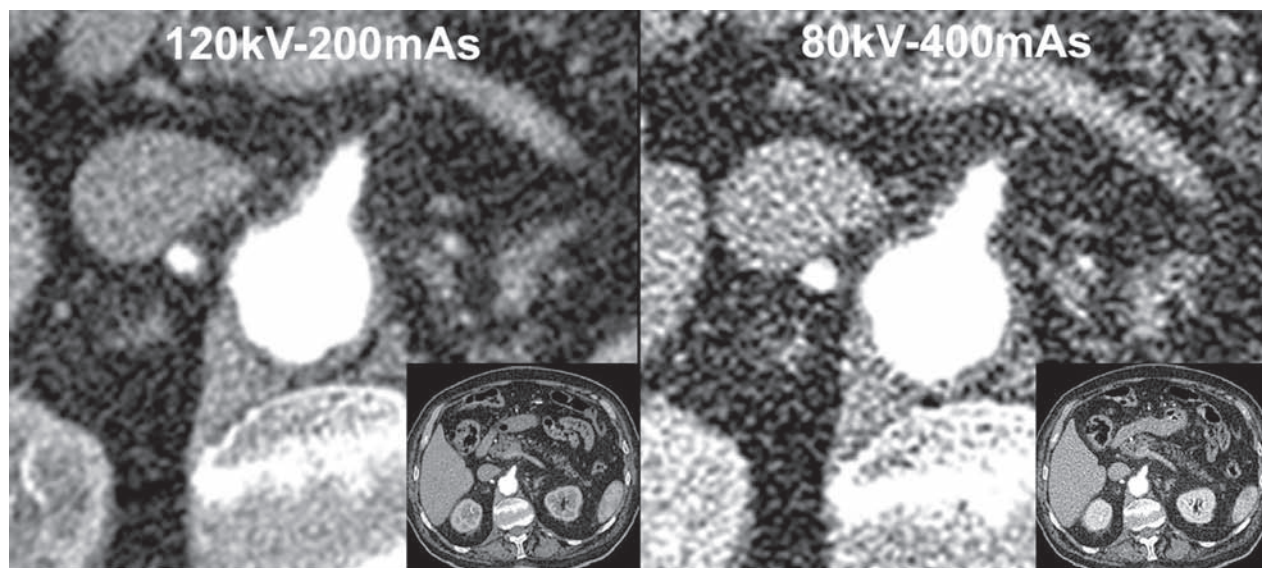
Abdominal CT angiography example. The figure shows axial images reconstructed with 1.5 mm of thickness at the level of the origin of superior mesenteric artery. On the right side there is the standard scan at 120kV and 200mAs of reference current and on the left side there is the scan at 80kV and 400mAs of reference current. The images are alike and the image noise increase at 80kV is compensated by a high intravascular attenuation
